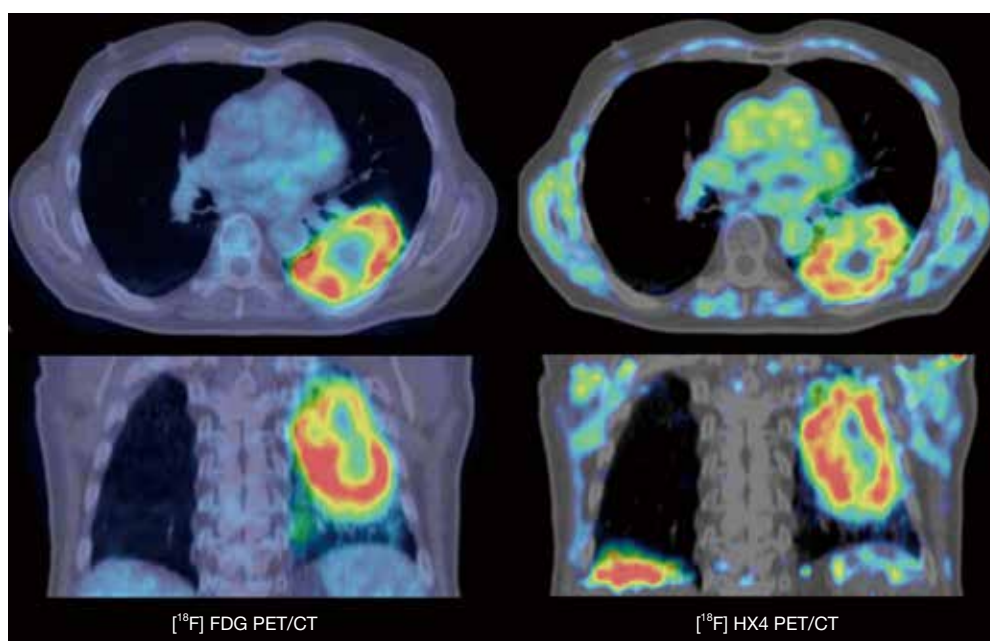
Example of a NSCLC patient having both an FDG-PET/CT scan (left) and a hypoxia HX4-PET/CT scan. Clearly visible is the tumour heterogeneity both on the metabolic (FDG) and hypoxic (HX4) PET image.
